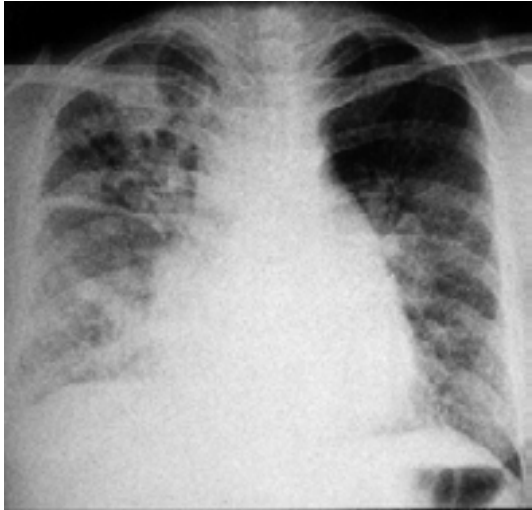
Chest roentgenogram on admission shows diffuse alveolar and interstitial infiltrates in both lung fields and a pneumatocele in the right upper lung field.
